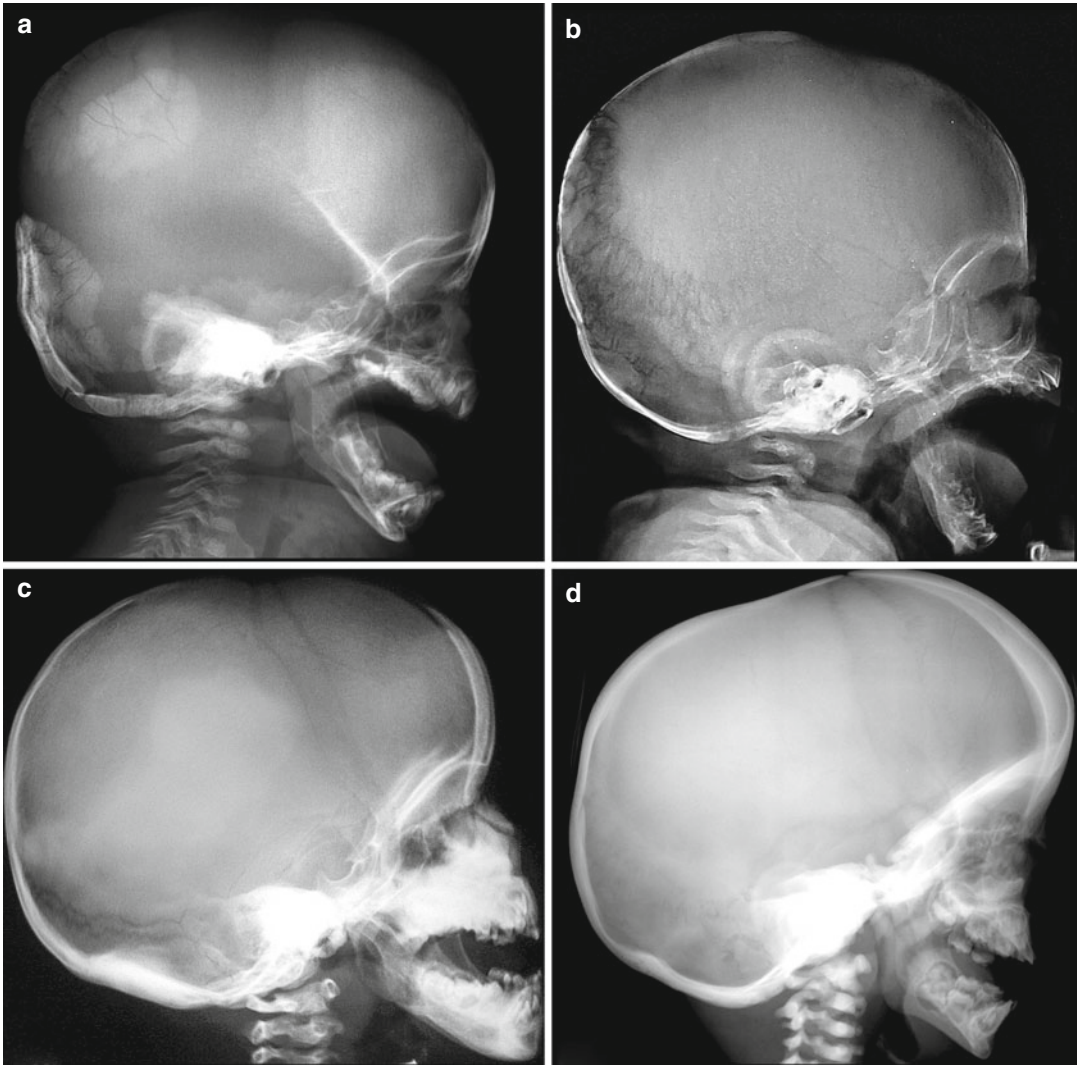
Lateral skull radiographs. (a) Newborn with severe hypophosphatasia (recessive alkaline phosphatase (*TNSALP*) mutations): they are ossification “island” in the occipital, parietal, and frontal regions with large unossified lacunae in between. Wormian bones (mosaic-like) can be seen within the ossified regions. The patchy ossification is typical for severe hypophosphatasia and can be seen in the spine as well. (b) Newborn with osteogenesis imperfecta (dominant *COL1A1* mutation). There is general poor mineralization with numerous Wormian bones in the occipital region. (c) 3-year-old girl with dominant craniometaphyseal dysplasia (heterozygous mutation in the *ANKH* gene coding for a pyrophosphate transporter):
